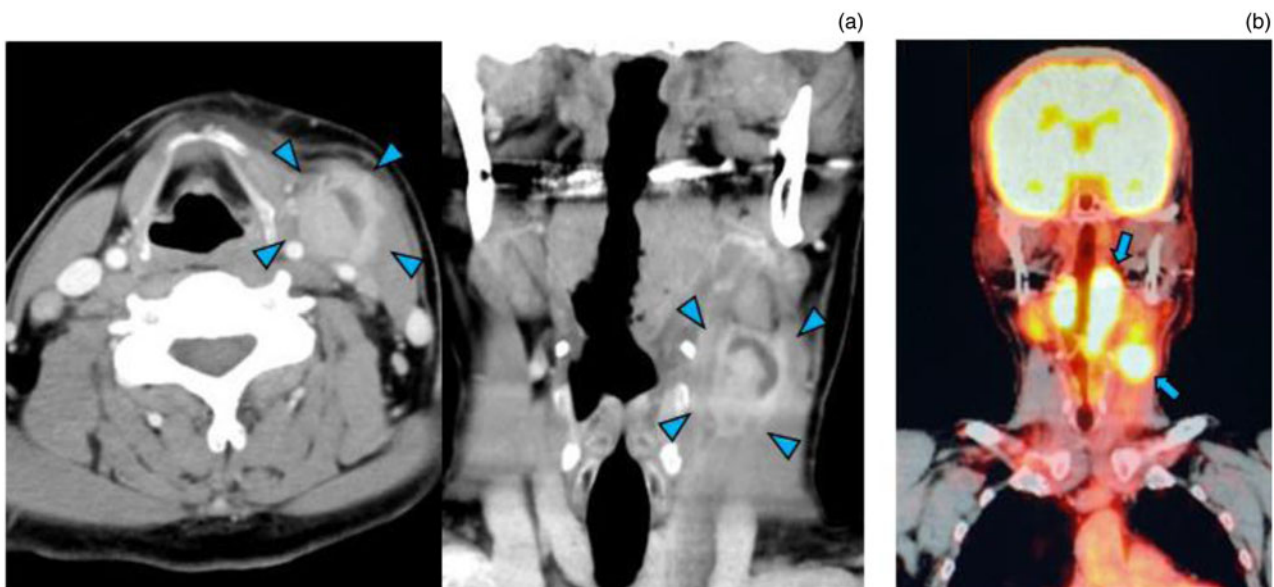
Imaging. (a) Contrast-enhanced computed tomography (CT); and (b) positron emission tomography - CT. Contrast-enhanced CT (a) reveals an increase in the size of the lymph node, with a maximum diameter of 27 mm, and suspected cystic changes or internal necrosis (arrowheads). Positron emission tomography - CT (b) showed uptake in the left palatine tonsil and the enlarged cervical lymph node (arrows).
